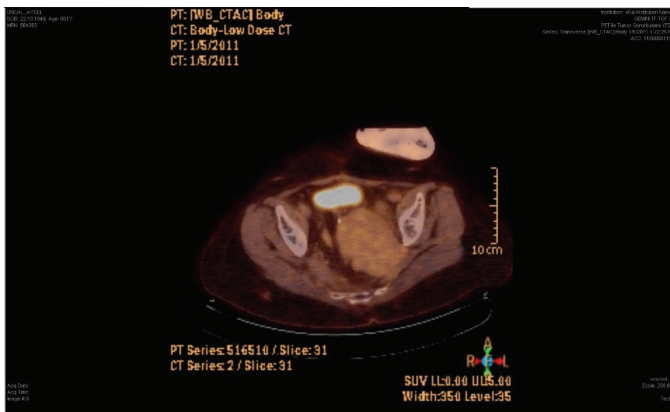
PET/CT shows left lateral wall invasion of LRRc
